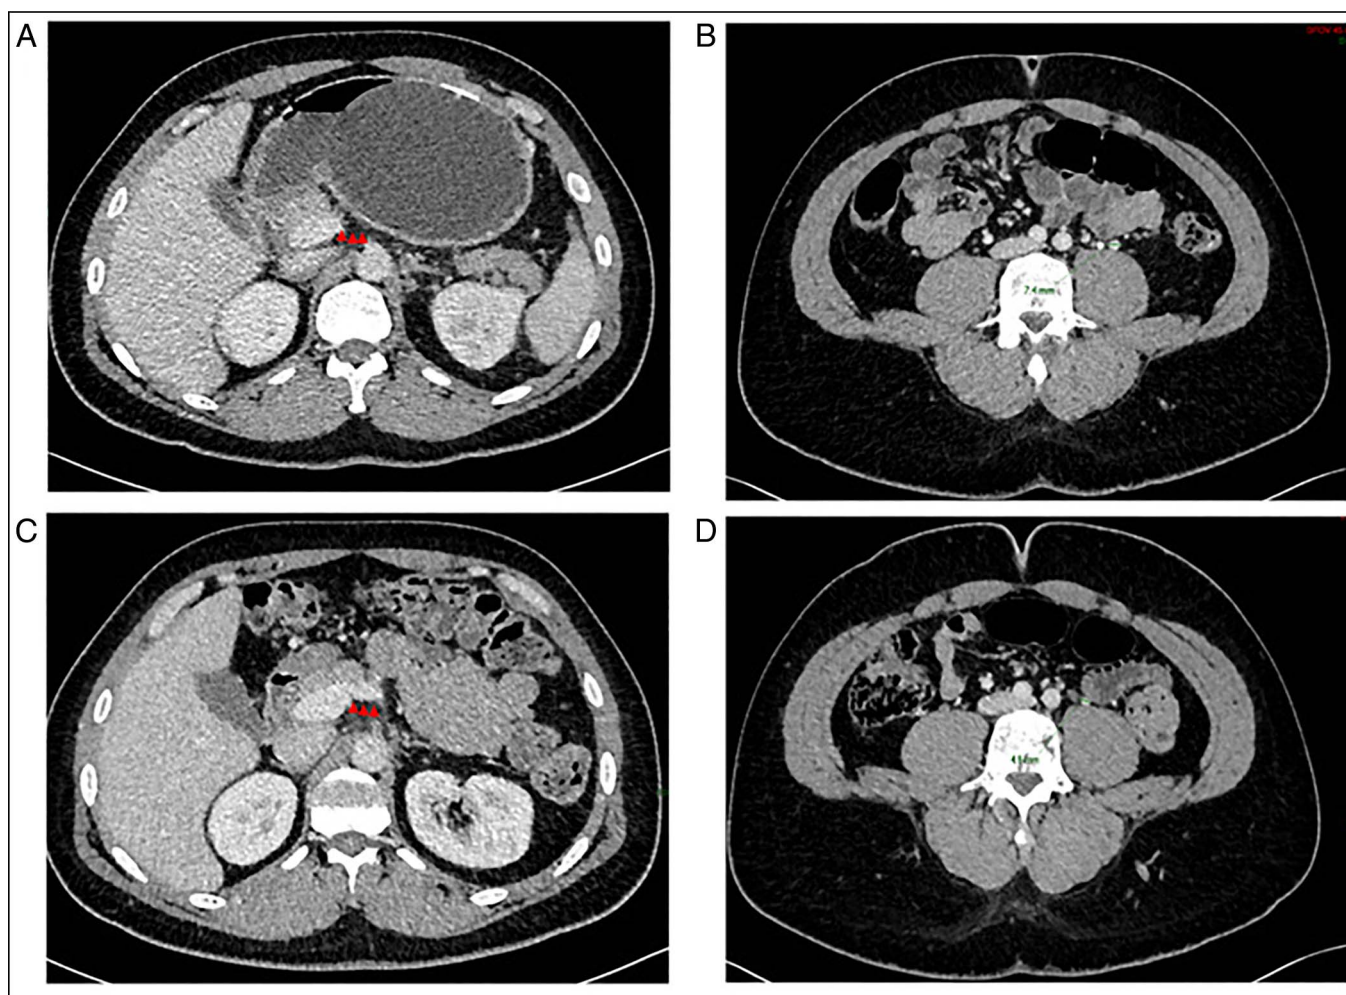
(A) Axial CT showing the intragastric balloon with nonvisualization of the splenic vein (arrowheads) at the level of the portal vein confluence likely secondary to gastric balloon mass effect or thrombosis. (B) Axial CT caudal to the aortic bifurcation shows a prominent gonadal vein of 7.4 mm in diameter. (C) Axial image after removal of the intragastric balloon shows recanalization of the splenic vein (arrowheads). (D) Interval improvement of the dilated left gonadal vein of 4.9 mm in diameter. CT, computed tomography.
